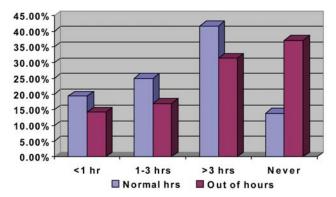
Time to obtain ultrasound in and out of regular working hours.
